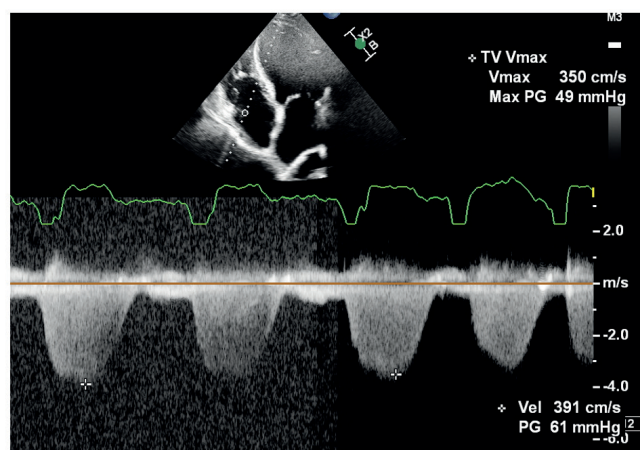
TR on continuous-wave Doppler with excessive gain (left, with a maximum velocity of 3.9 m/s) and with appropriate gain (right, with a maximum velocity of 3.5 m/s).
